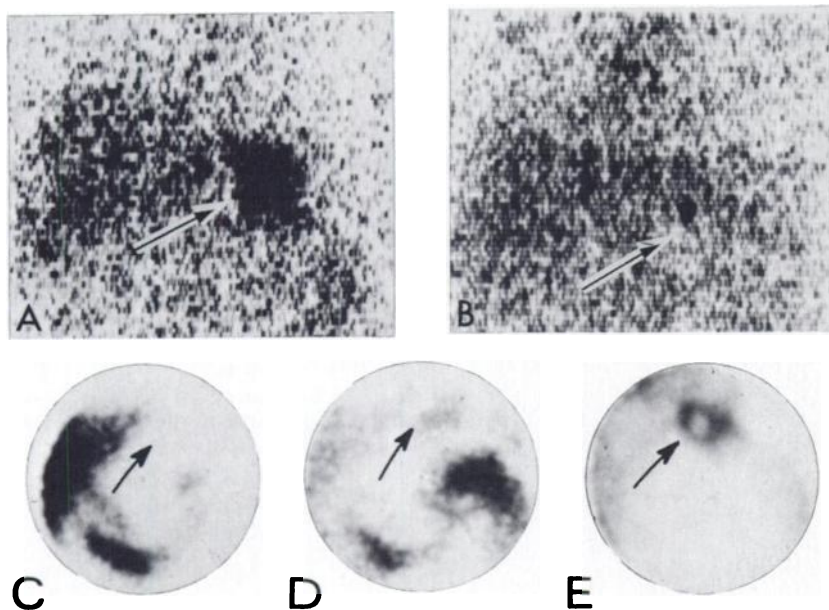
Scintigrams of stomach region in Patient 1. Anterior view (A) shows abnormal left upper quadrant accumulation (arrows) in stomach 3 days after i.v. injection of 3 mCi Ga-67 citrate. Posterior view (B), imaged at same time, shows same accumulation faintly. Abnormal radioactivity remained after patient was given a drink of water. Slight persisting radioactivity is also noted in region of splenic flexure. Anterior rose bengal (I-131) scintigram (C) was imaged just before a meal, 40 min after tracer injection (150 μCi). Another image of same region (D), 5 min after meal, shows reflux of hepatobiliary marker into stomach. Anterior stomach image (E) was obtained 20 min after injection of 2 mCi of Tc-99m as pertechnetate; it confirms stomach location.
